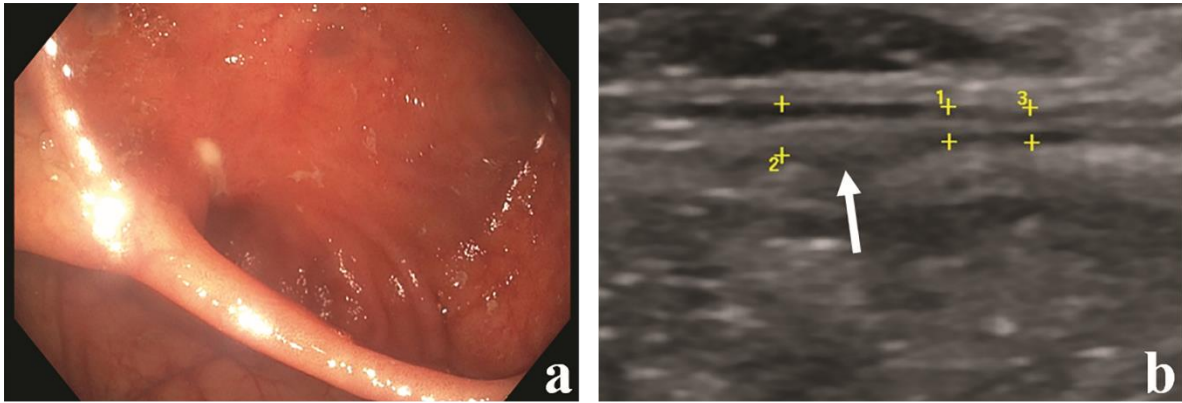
Neoterminal ileum with a solitary aphthous lesion at endoscopy (a). There were normal findings at ultrasonography (b). The arrow shows the neoterminal ileum on GIUS.
